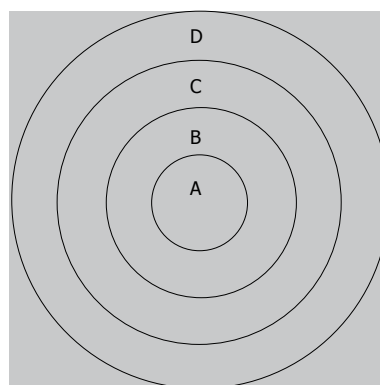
A: The area of VX-2 tumor center; B: The area of VX-2 tumor periphery; C: The area of VX-2 tumor outer layer; D: The normal liver parenchyma area around tumor when the values of ADC and signals were measured on DWI and samples were investigated pathologically.
